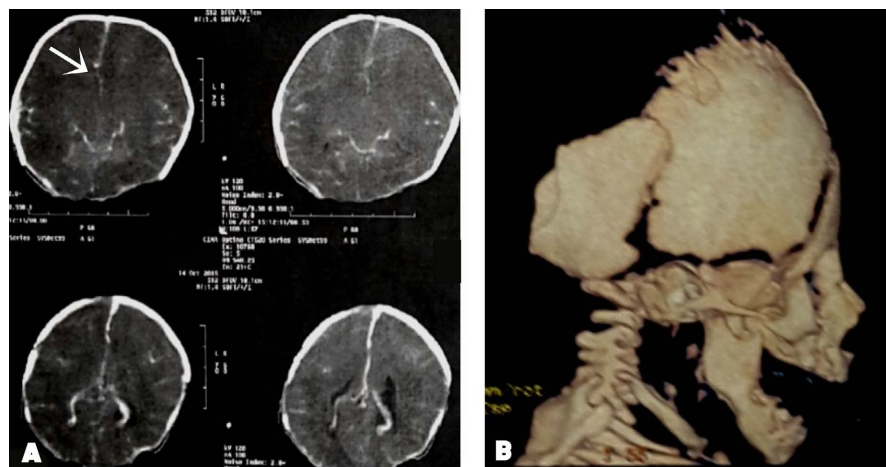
Brain CT scan showing parenchymal and bony malformations (A) Agenesis of the corpus callosum and diencephalic structures (showed with the white arrow) (B) Cranioencephalic CT scan; 3D reconstruction. Hypoplasia of the bones in the vault (occipital, parietal, temporal, frontal).
